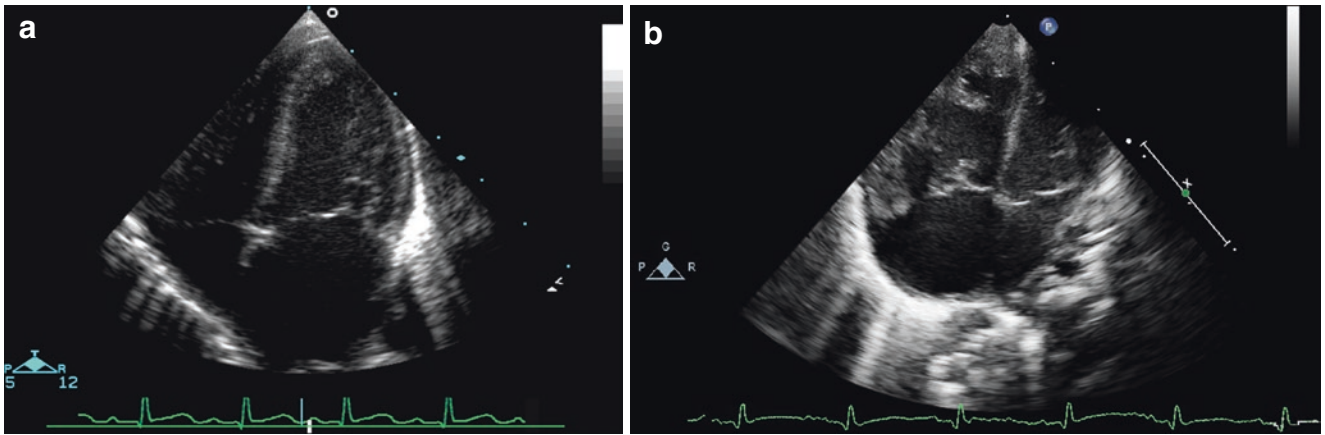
Apical four-chamber view in a patient with large perimembranous VSD and low pulmonary vascular resistance exhibits dilatation of the left atrium and ventricle due to excessive LR-shunting (a). In a patient with perimembranous VSD and elevated pulmonary vascular resistance, the right ventricle is hypertrophied and enlarged (b)
